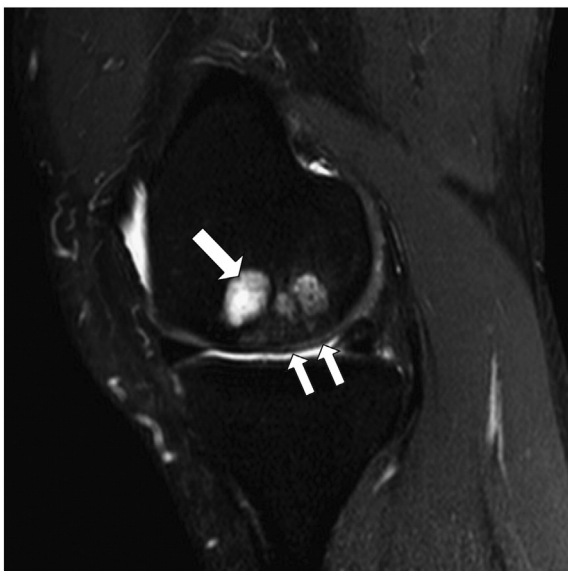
Magnetic resonance imaging (1 T) of an osteochondral lesion of the medial femoral condyle treated with a TruFit plug 2 years before. Sagittal spin-echo intermediate-weighted with fat saturation (TR: 3500 ms; TE: 30 ms; FA: 90°; ST: 3 mm; FOV: 18 cm). Despite good scaffold integration and partial filling of the chondral layer (double arrow), subchondral bone changes were clearly seen (arrow) in this MRI sequence.
